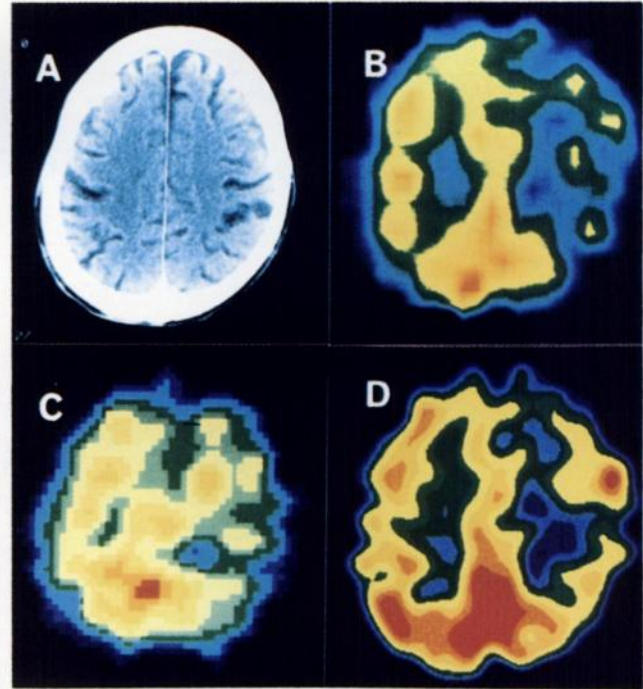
Three SPECT images obtained 90 mm above OM the line in a case of the right internal carotid artery occlusion without massive low density areas on brain CT (Patient 12). (A) Brain CT. (B) rCBF images obtained with ^{133}Xe . (C) The functional map obtained by our method. (D) The conventional [^{123}I]IMP image.
